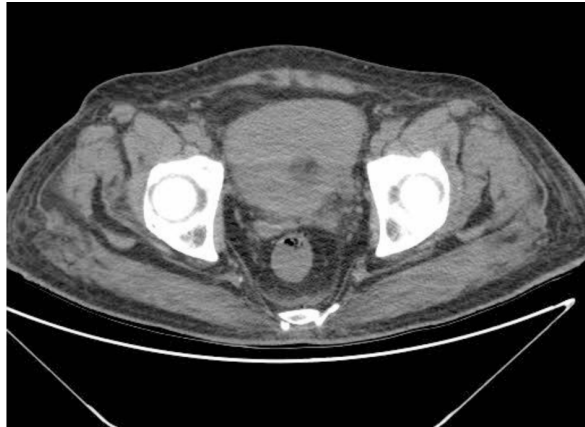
CT scan on the 10th day of the treatment revealed cure of bladder wall.
